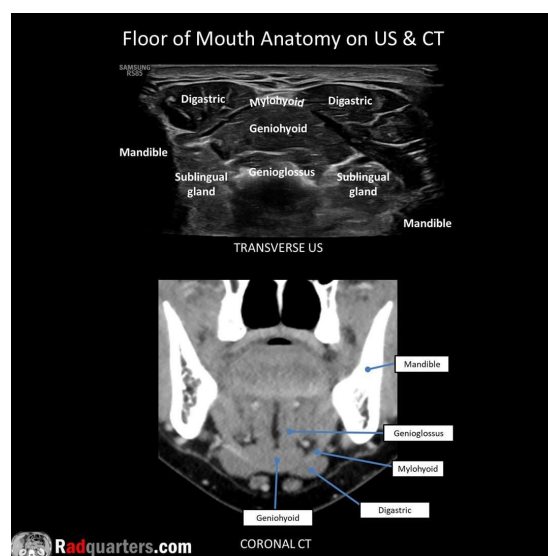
Ultrasound image of floor of the mouth showing muscles of floor of the mouth.
